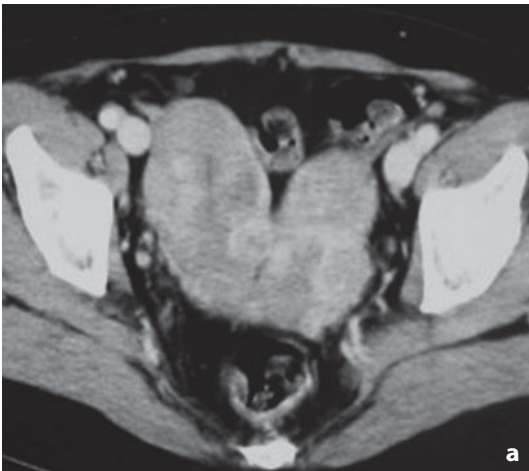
Computed tomography. Multiple intramural leiomyomas in a bicornuate uterus, the profiles of which appear deformed. Axial image (a) and coronal reconstruction (b)
